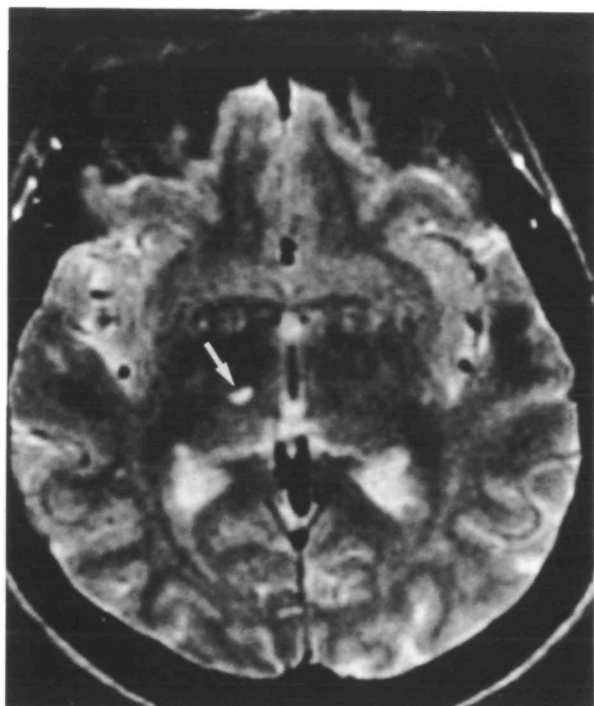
$T_2$ -weighted magnetic resonance imaging revealing lacunar infarction in the area corresponding to ventralis posterior nucleus (arrow).
